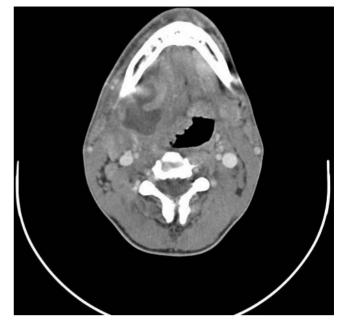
Axial contrast-enhanced CT scan showing abscess in the right submandibular space (different patient to Figure 40.5). A large hypodense area medial to the mandible is evident with ring enhancement and oedema affecting the soft tissues superficial and deep to the abscess. The pharyngeal lumen is narrowed and shifted to the contralateral side.
